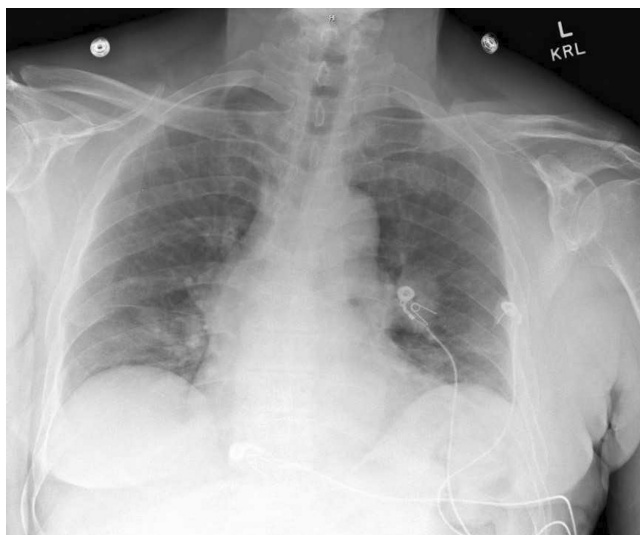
Initial chest x-ray showing a mass like consolidation on the left lung.
